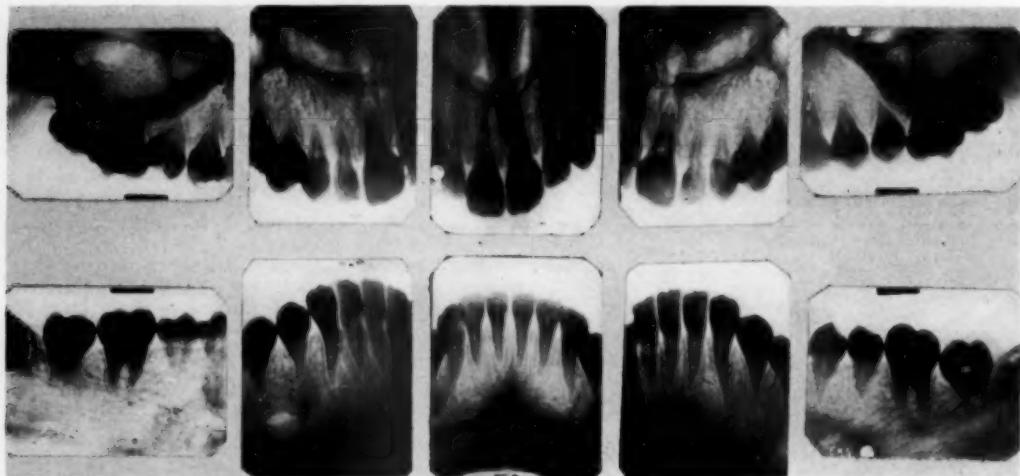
Intraoral roentgenograms of a condition characterized by a markedly deficient amount of root formation. This condition may be familial (Ballschmiede, quoted from Landsberger¹⁰). The eruption time of the teeth was normal although root formation is markedly deficient. (Courtesy of Dr. S. Kloehne.)
